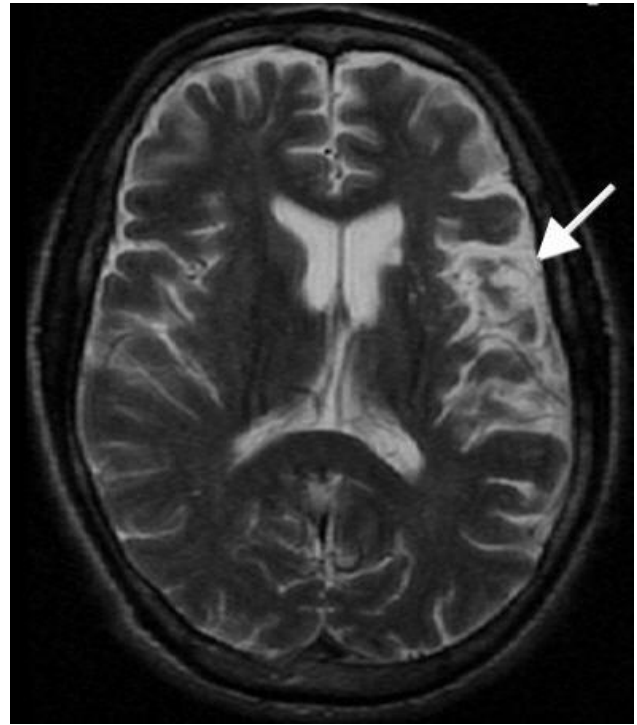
Brain MRI without contrast (axial T2 weighted sequence): Old infarct in left parietal region (arrow).
